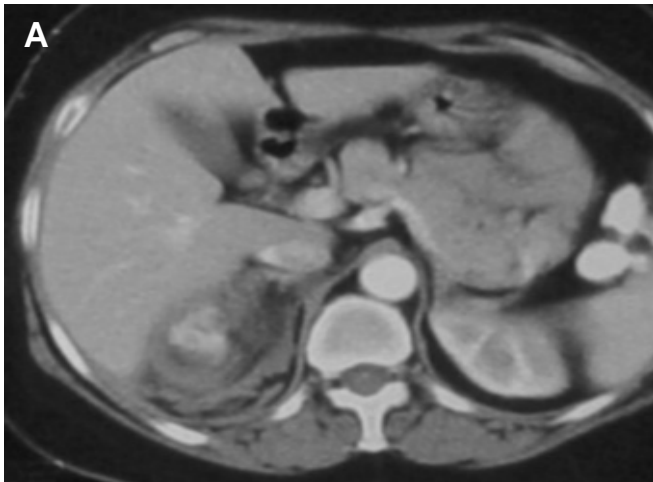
A. Arterial phase CT scan shows enhancing structure (arrow) in upper pole of right kidney. B. Contrast CT scan with 10-min delay shows washout focal enhancement of pseudoaneurysm, compared with A.
